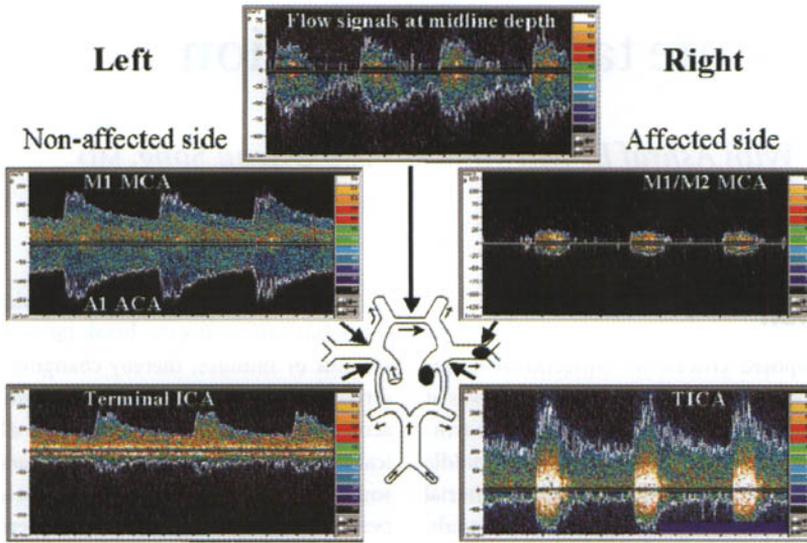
Transcranial Doppler waveforms in a patient with acute tandem ICA/MCA occlusion.
